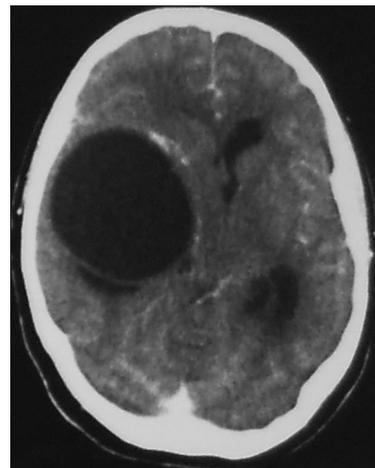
CT scan brain with contrast revealing no enhancement of the lesion
